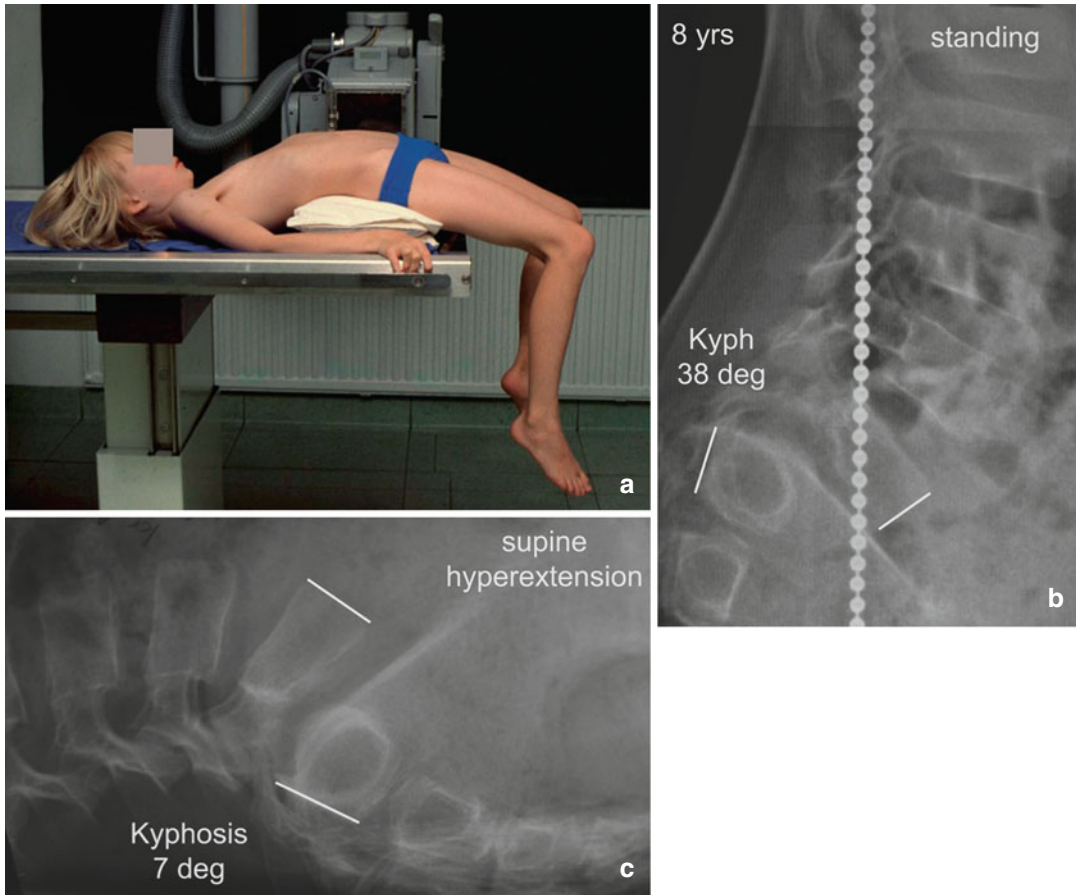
(a) Patient positioning for the lateral supine hyperextension radiograph of the lumbosacral junction in high-grade slips. (b) Standing lateral radiograph shows
